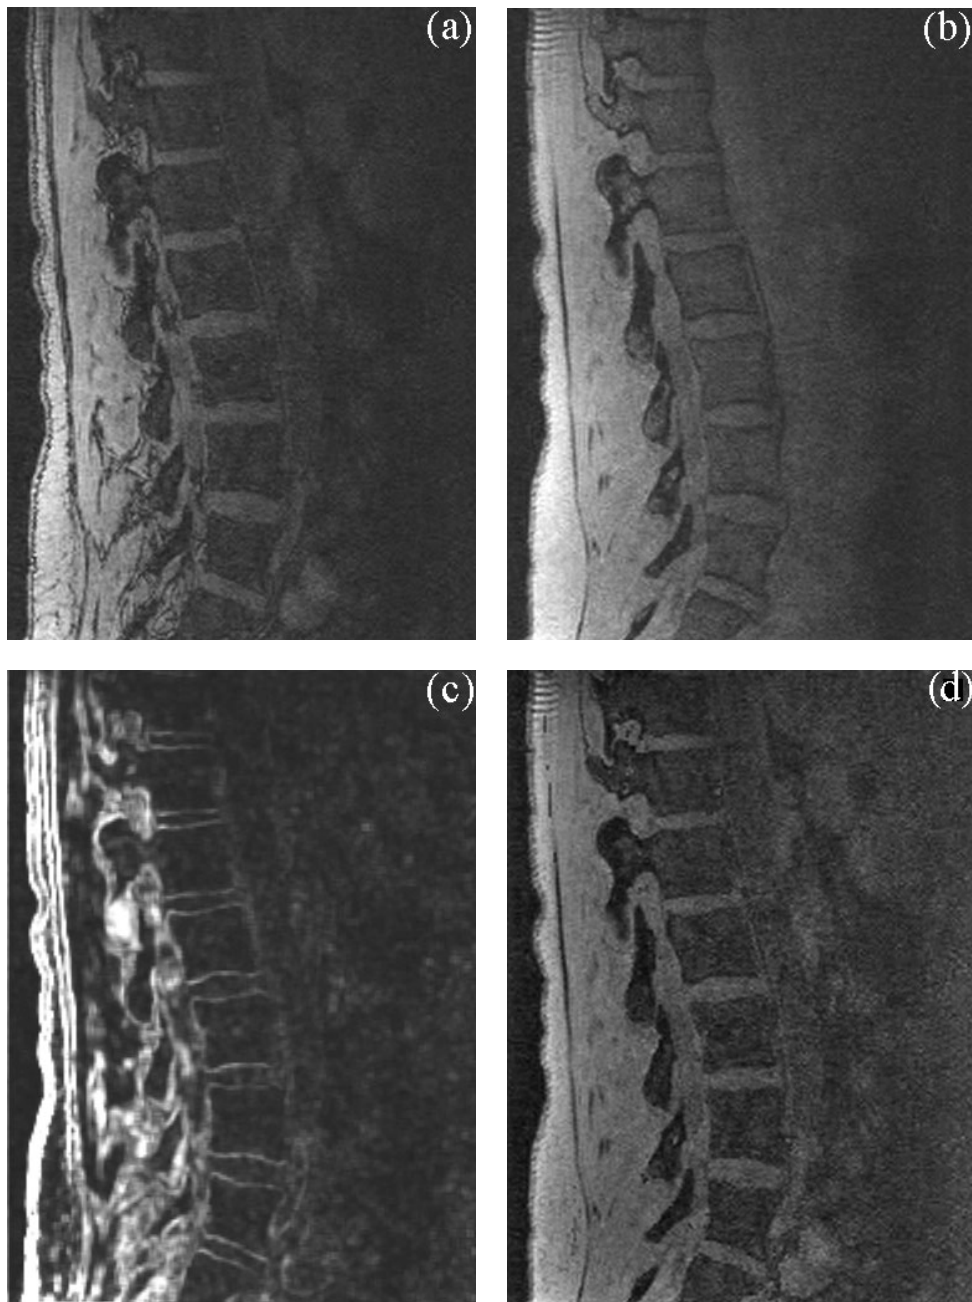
Examples of a typical sagittal slice MR image from the FISP sequence including processed data. (a) echo 1, (b) echo 2, (c) statistical variance data for slice and (d) resulting combined data showing good overall contrast between bone (dark) and surrounding soft tissue (light).
